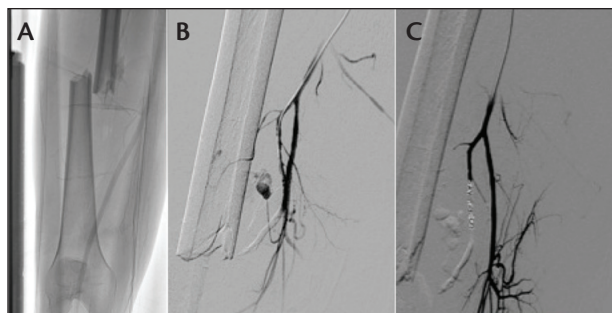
Femur x-ray demonstrating a transverse, displaced fracture of the femur shaft (A). Selective superficial femoral artery angiogram showing the source of the active bleeding next to the femoral fracture (B). Control angiogram after gel-foam and coil embolization (C).
